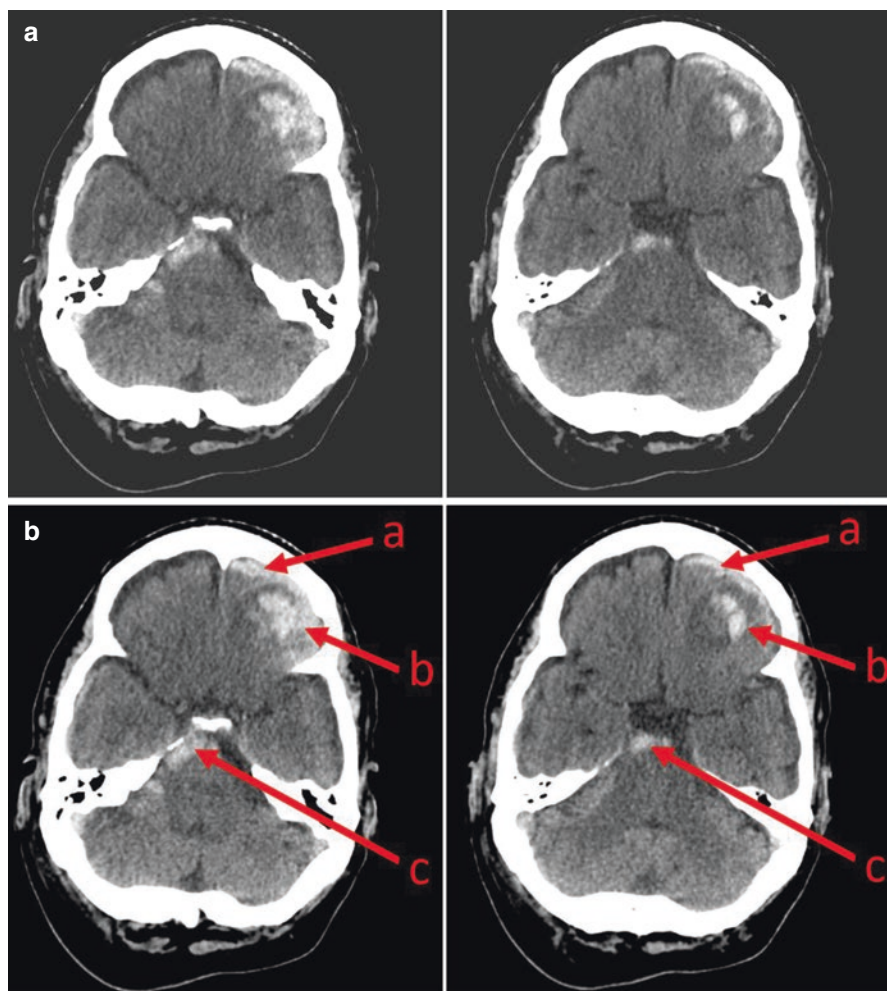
(a) Axial images of a CT without contrast of a 55-year-old male found down and altered, see (b) for labeled pathology. (b) Axial images of a CT without contrast obtained for altered mental status. (a) Left frontotemporal subdural hemorrhage, (b) left frontal intraparenchymal hemorrhage, (c) subarachnoid hemorrhage in right cerebellopontine cistern. Courtesy of Perrin Considine
